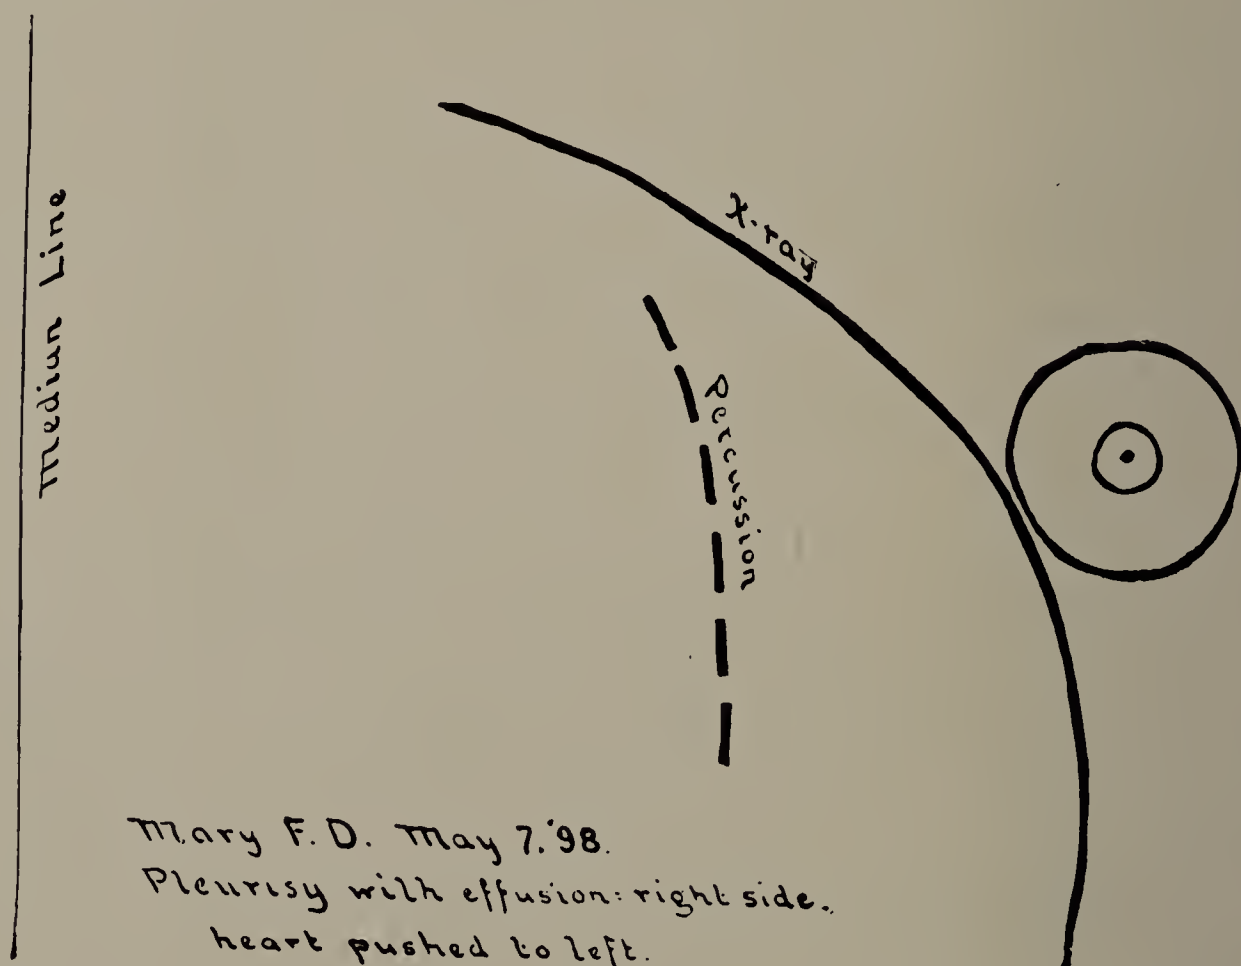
Mary F. D. May 7, 1898. X-ray tracing. Full line shows the left border of the heart; broken line shows this border as determined by percussion. (Cut one-third life size.)
